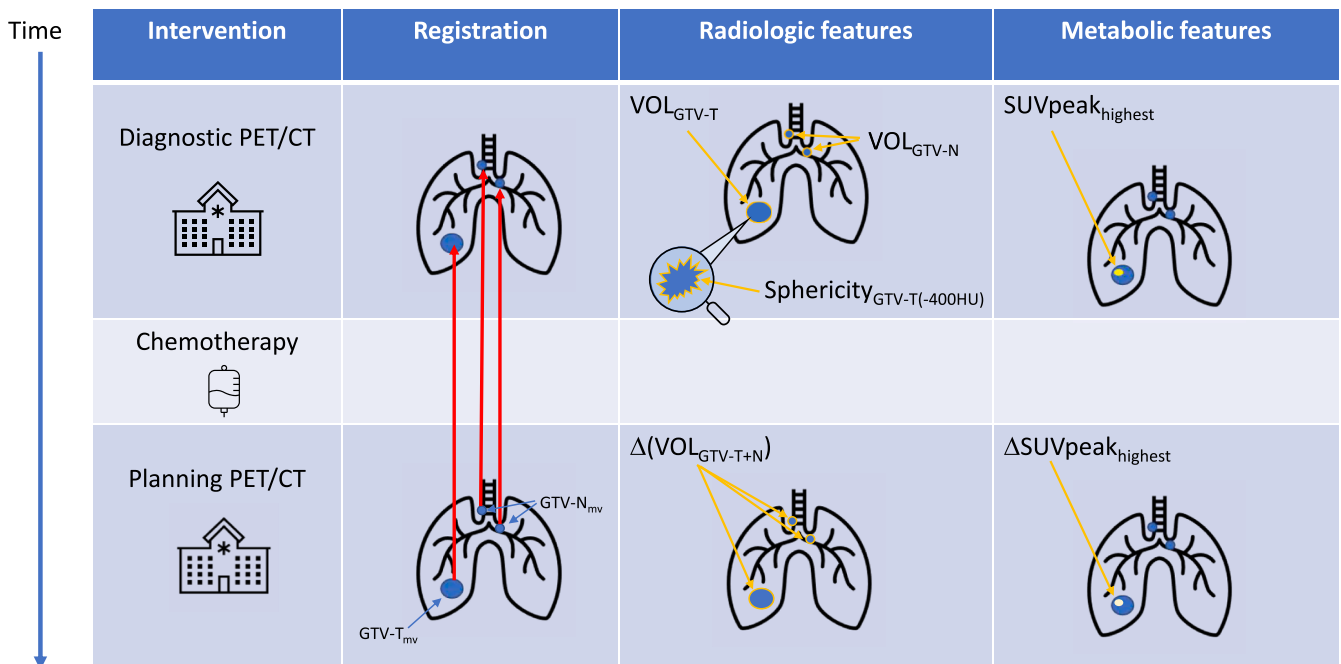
Study design. Mid-ventilation planning target structures of GTV-T and GTV-N were registered from the planning PET/CT to the diagnostic PET/CT and corrected if needed. Features for response assessment were extracted from each scan. These included radiologic features (volume and sphericity) in addition to the metabolic feature of SUV_{peak} . The change in total disease volume ($\Delta(VOL_{GTV-T+N})$) was calculated from the diagnostic to the planning CT. The lesion with the highest SUV_{peak} on the diagnostic PET was identified on the planning PET and the change ($\Delta SUV_{peak_{highest}}$) was calculated. Abbreviations, GTV-T: gross volume of target tumour, GTV-N: gross volume of target lymphnodes, $GTV-T(-400HU)$: gross volume of target tumour subtracted Hounsfield units below 400 (air).
